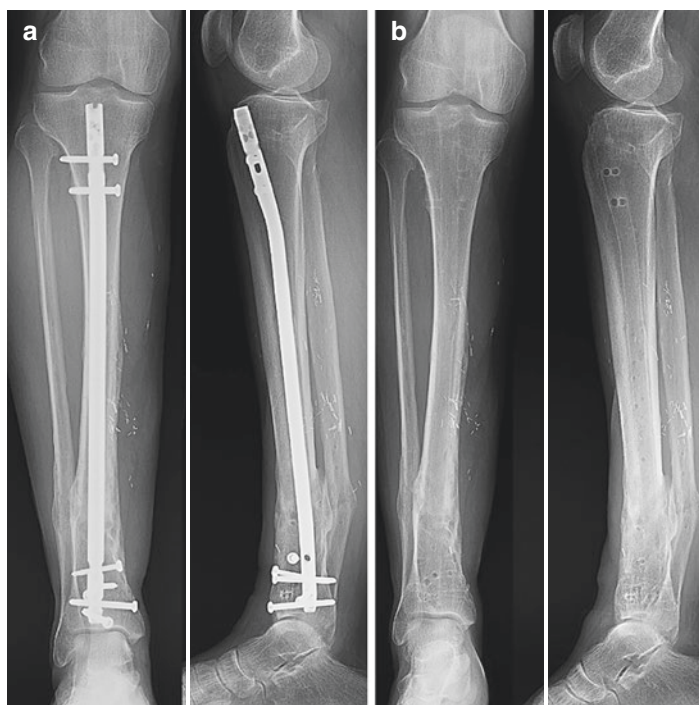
(a) AP and lateral radiographs at the final follow-up before hardware removal showing a healed distal tibia-fibula fracture with intact hardware. (b) AP and lateral radiographs at the latest follow-up after hardware removal showing a healed tibia with no hardware in place
